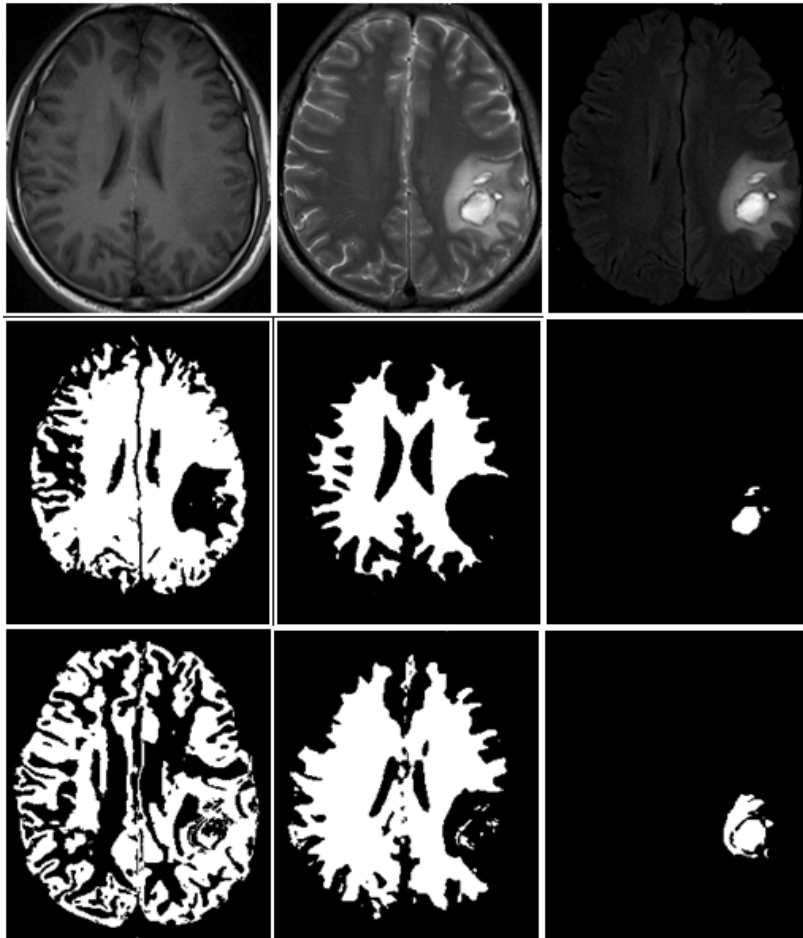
Classification Results using Dataset 1: (from left to right) top row - Input Slices T1WI, T2WI and FLAIR image, middle row- ICA Results, GM, WM and Abnormal Tissue, bottom row-MICA Results GM, WM and Abnormal Tissue
